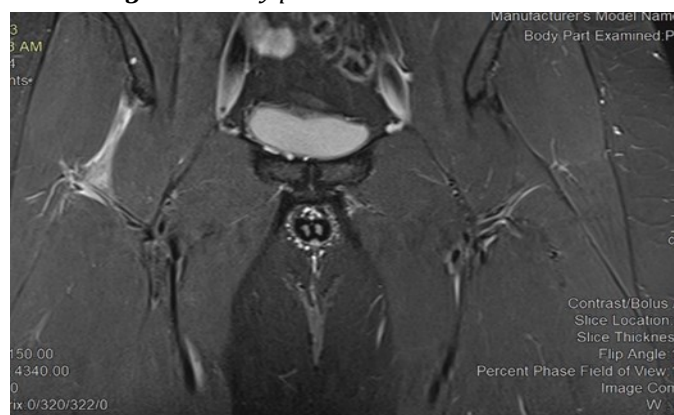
MRI pelvis, axial cut showed avulsion of right rectus femoris from origin.
